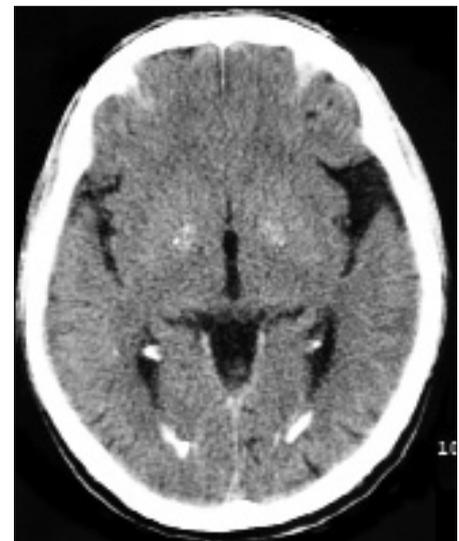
CT scan at basal ganglia level
